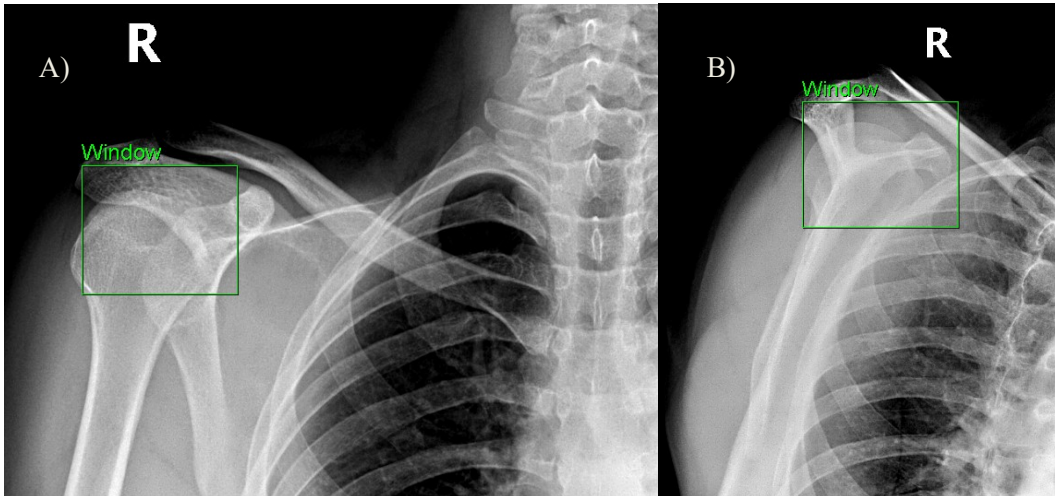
Patient radiographs of the right shoulder post-relocation: (A) AP with internal rotation and (B) Scapular-Y view. Although not identified on the initial imaging report, a subtle cortical defect is suspected, particularly on the AP with internal rotation view.
